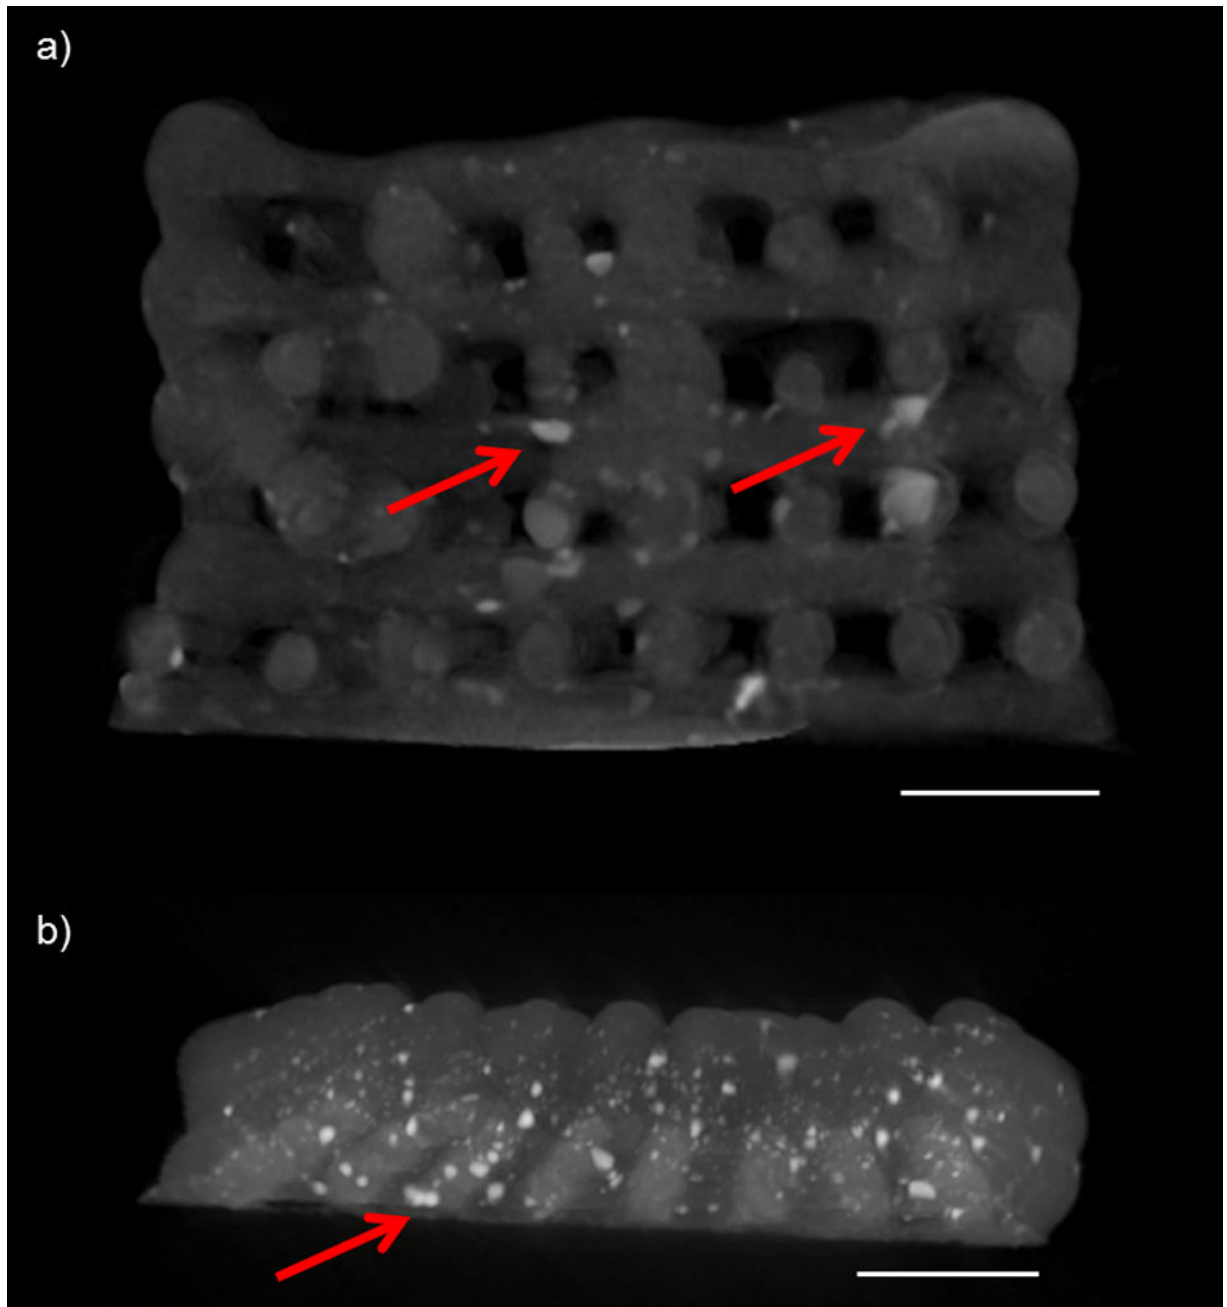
Cross-sectional images of (a) a PPF-HA scaffold without SDS (containing a uniform concentration of HA) and (b) a PPF-HA gradient scaffold. Images generated from a 3D reconstruction via μ CT. Scale bars in both images = 2 mm. Arrows point to noticeable aggregates of HA, which are apparent as white, opaque clusters within dark gray PPF matrix.
